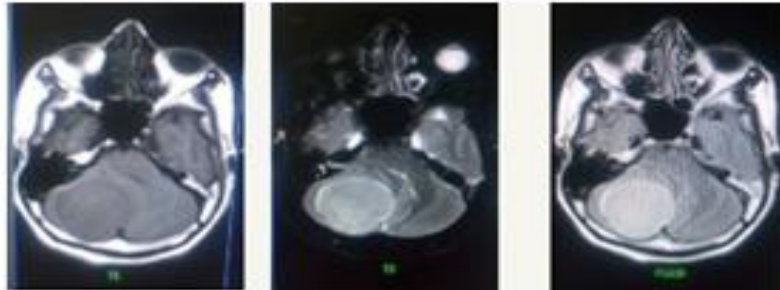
T1, T2 and FLAIR image sequence of brain MRI
